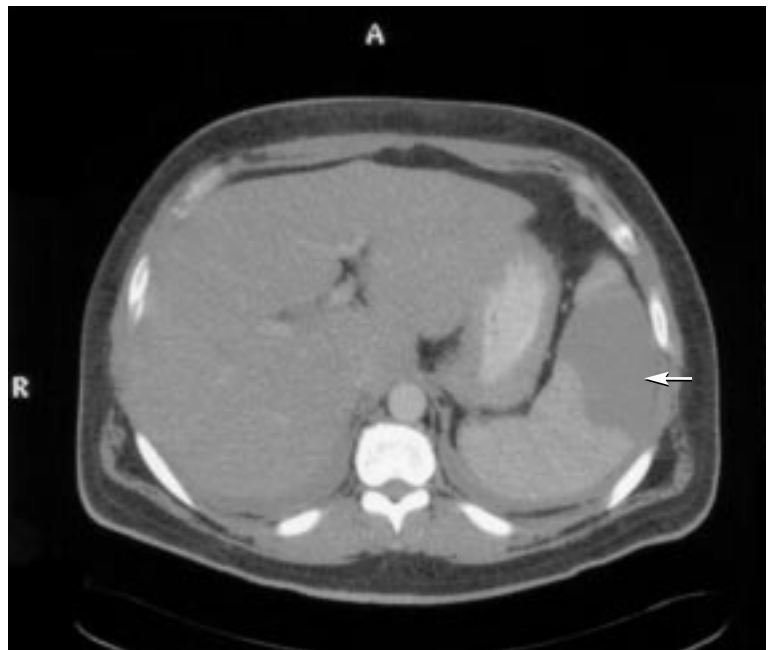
Computed tomographic scan of the abdomen showing a large area of low attenuation within the supero-lateral spleen with sharp, wedge-shaped borders, likely representing splenic infarction (arrow).
